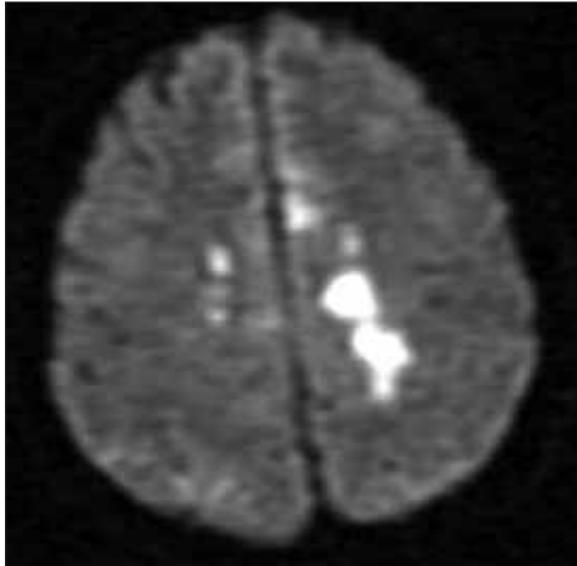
Preoperative DWI showing restriction in posterior frontal region.
